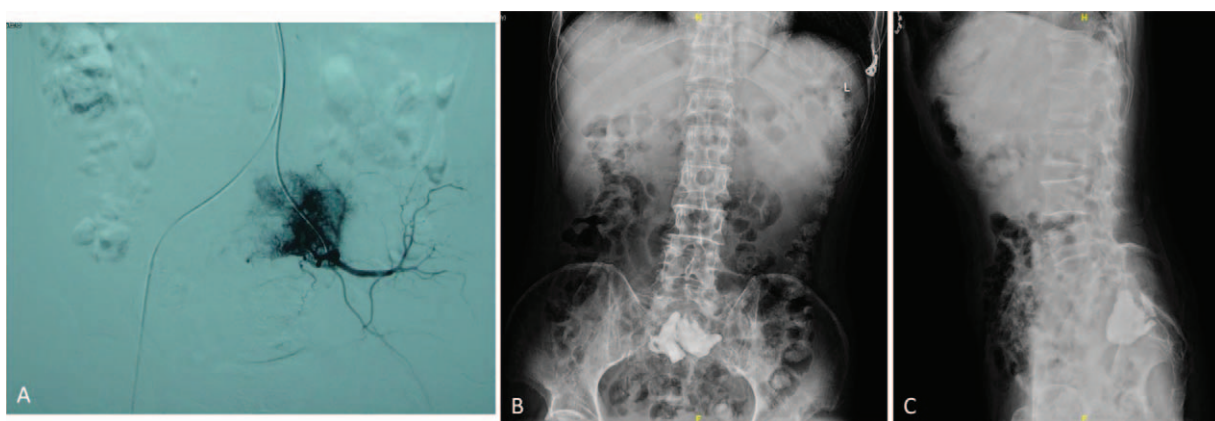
(A) Embolization of the internal iliac artery was performed under local anesthesia. (B) Posteroanterior (PA) x-ray image of the spine obtained postoperatively. (C) Lateral x-ray image of the spine obtained postoperatively.
